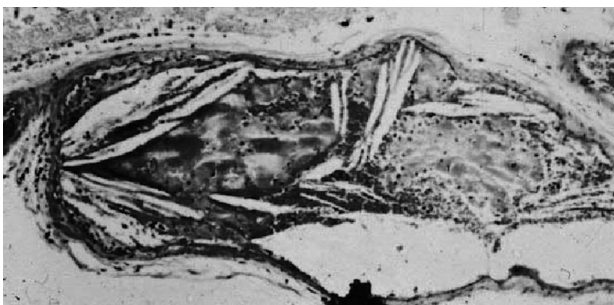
An embolus of atherosclerotic debris in a cerebral blood vessel. Emboli of atheroembolic debris laden with cholesterol crystals (the pointed slender white structures seen in this image) are not prevented by antiplatelet agents; they are prevented by endarterectomy. Stents with a fine mesh might prevent many such emboli, but open stents will not. Intensive medical therapy reduces microemboli detected on transcranial Doppler in patients with asymptomatic carotid stenosis.
